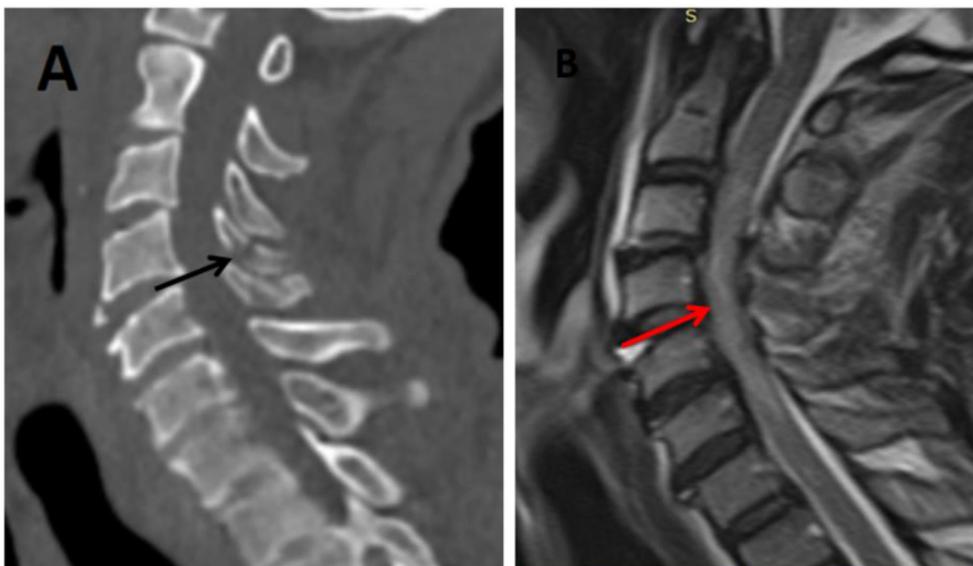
(a) CT scan of cervical spine, sagittal view, bone window: shows nondisplaced fracture of C4 spinous process (black arrow). (b) MRI scan of cervical spine, sagittal view, T2 sequence: shows abnormally high T2 signal of the spinal cord (red arrow) (suggesting cord edema or contusion) with obliteration of the subarachnoid space around the spinal cord denoting secondary canal stenosis. CT, computed tomography.
